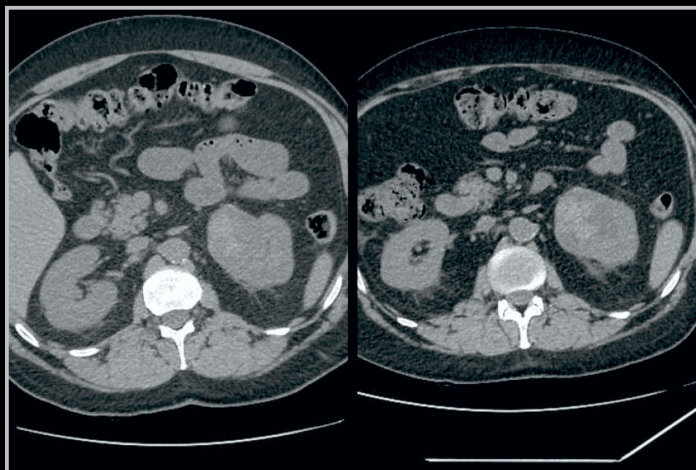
Abdominal CT scan - comparison of the Grawitz tumor between 2022 (left) and 2023 (right) showing minimal increase in dimensions- stable oncological aspect
